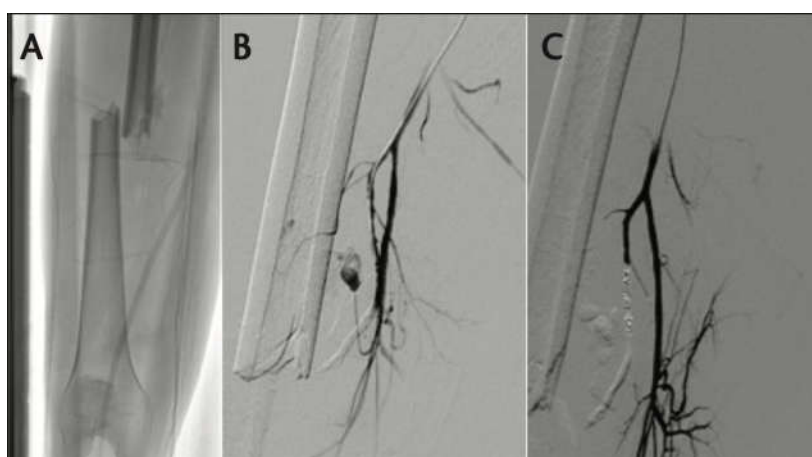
Radiograph showing displaced transverse fracture of the femoral shaft (A). Selective superficial femoral artery angiogram demonstrating bleeding source (B). Post-embolization angiogram showing successful hemostasis (C)[9]
